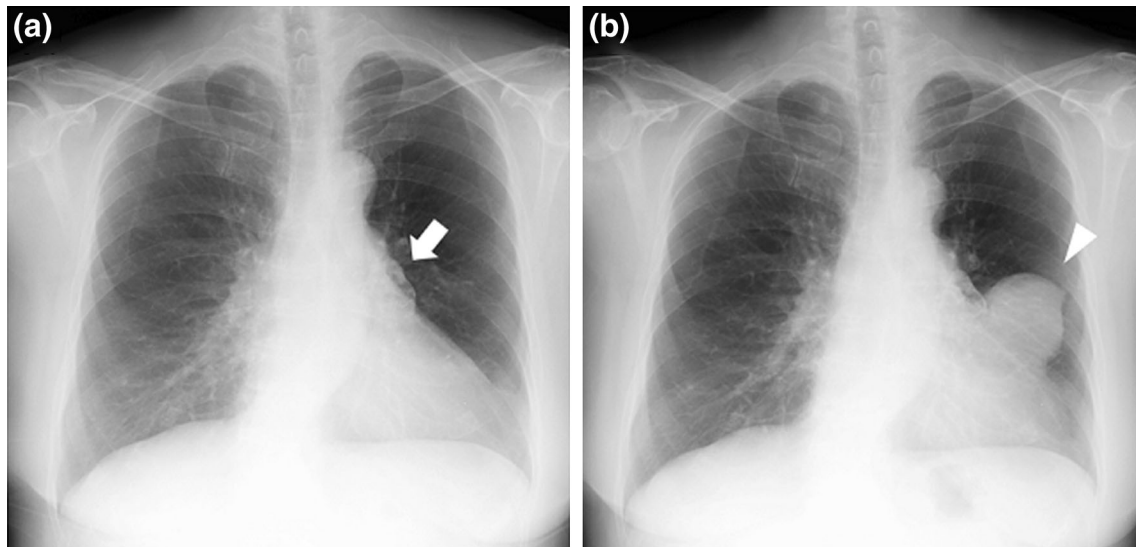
a Chest radiograph showed a calcified nodule in the left pulmonary hilum (*white arrow*). b Another mass emerged caudal to the initial nodule 3 years thereafter (*white arrow head*)
